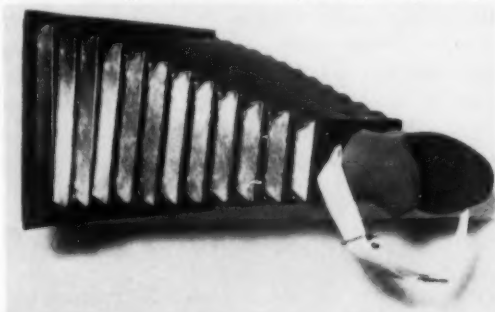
Apparatus for fluoroscopy in normal light, shielding the eyes of the examiner. (Bello-scope, Ampere X-Ray Co., New York City.)
